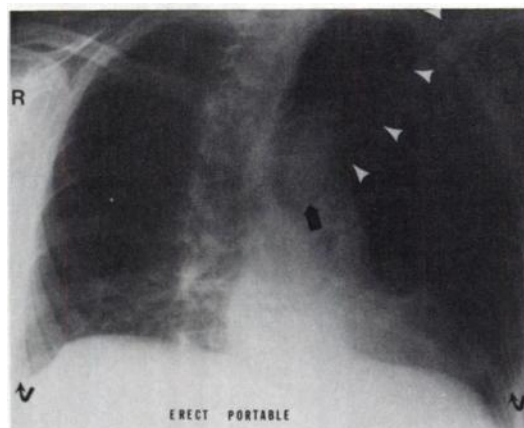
Portable, erect radiograph in right anterior oblique projection, obtained 9 hr before lung \dot{V}/\dot{Q} image, showing bilateral pleural fluid (bent arrows) and catheter tip above level of right atrium (black arrow).
